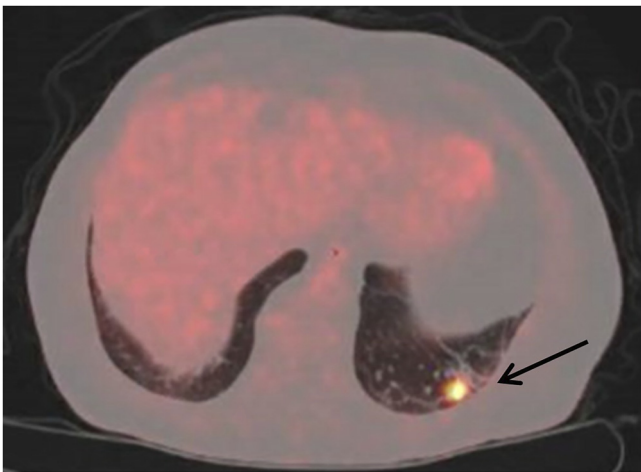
Sagittal section of PET-CT showing hypermetabolic left lower lobe pulmonary nodule (arrow)
